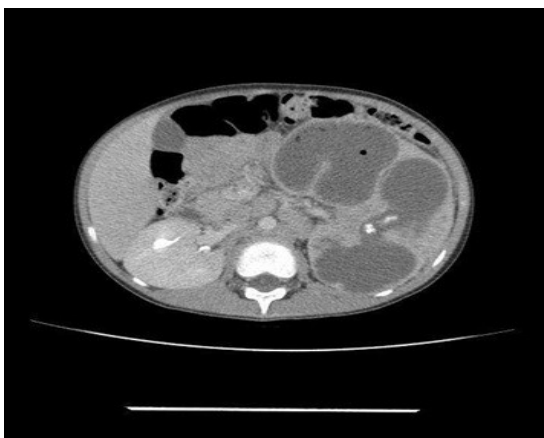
CT scan demonstrating left kidney enlargement associated with calculi and air bubbles in its interior, suggesting xanthogranulomatous pyelonephritis.
